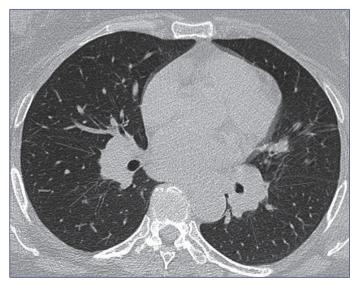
Bilateral hilar lymphadenopathies in HRCT (arrows).
